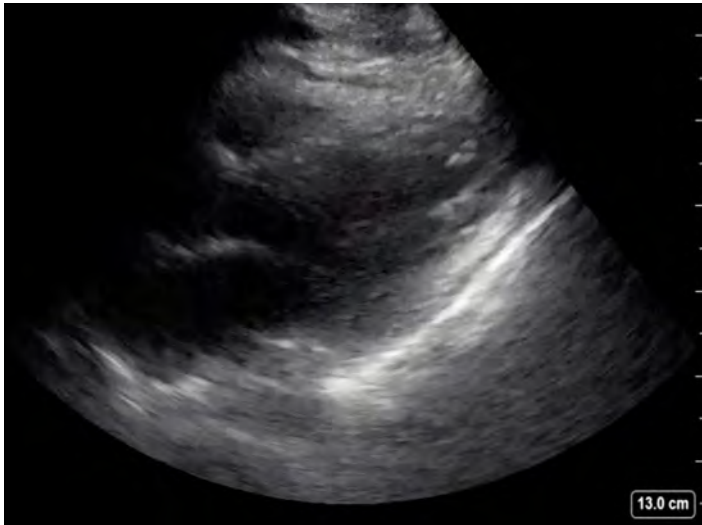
Normal systolic ejection fraction determined by parasternal long-axis view. Image acquisition via Sonosite X-Porte system using phased array probe.
